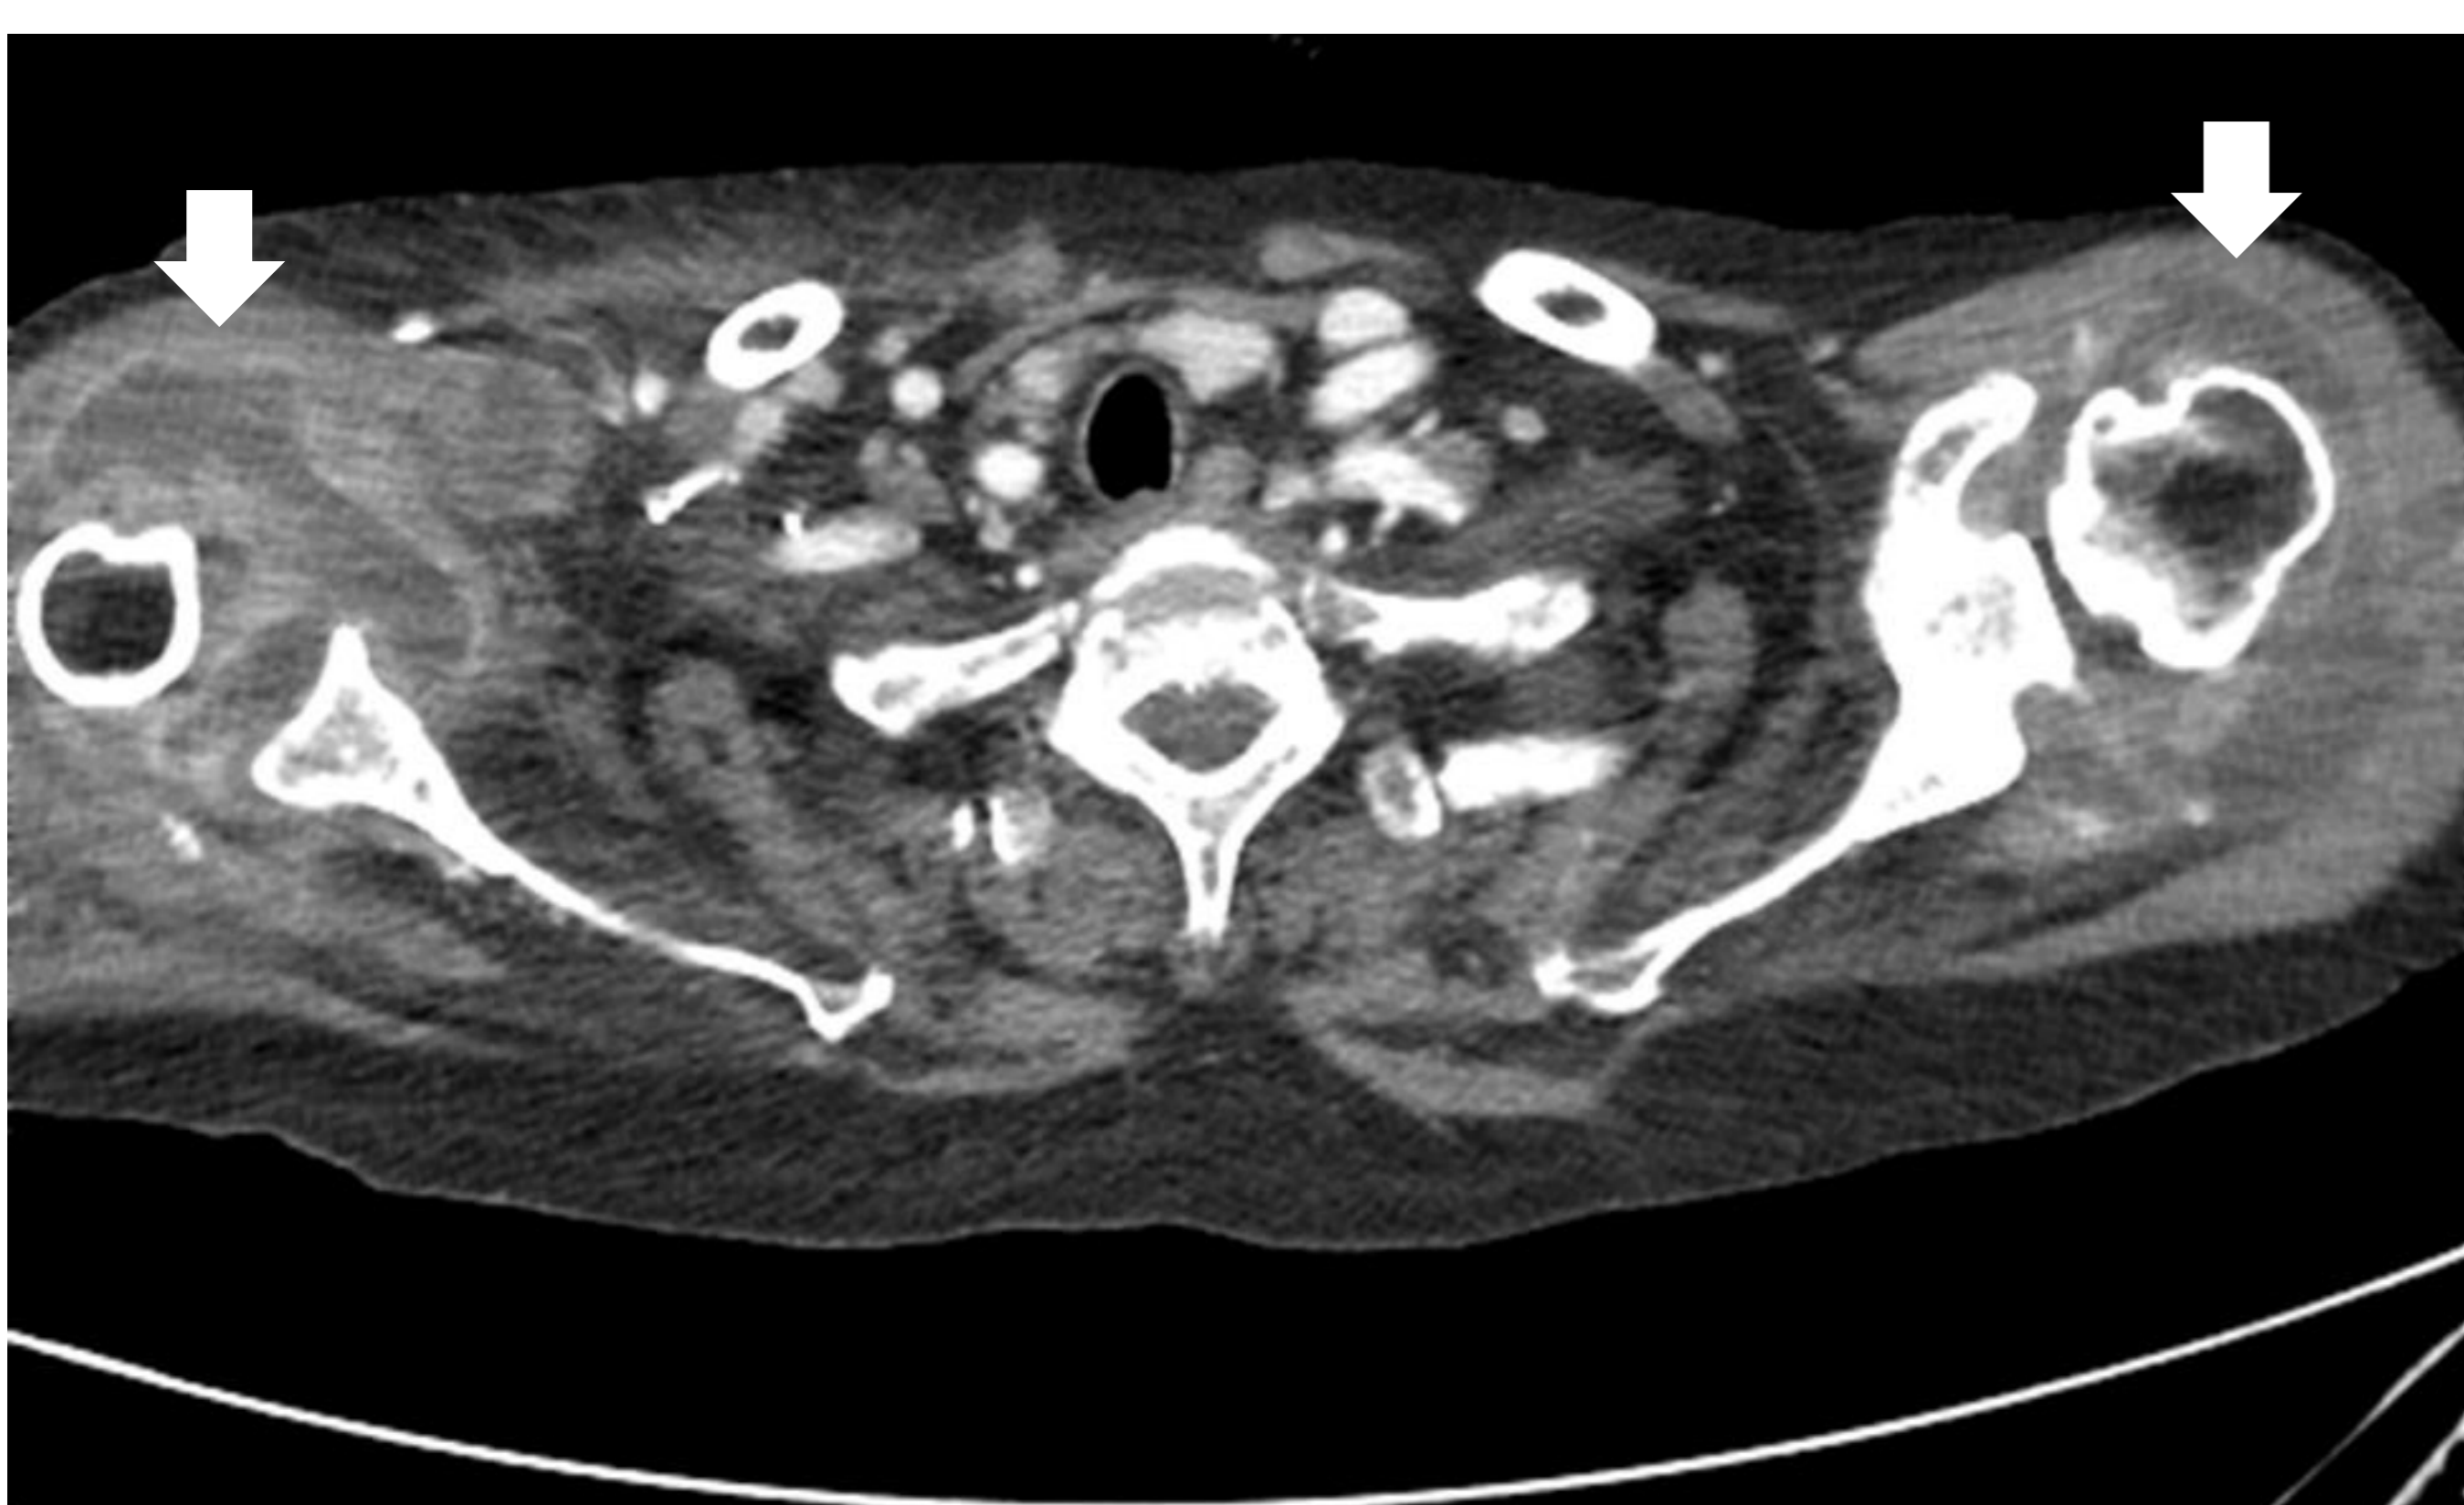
Axial contrast-enhanced chest computed tomography demonstrating fluid collection within the both glenohumeral joint.
